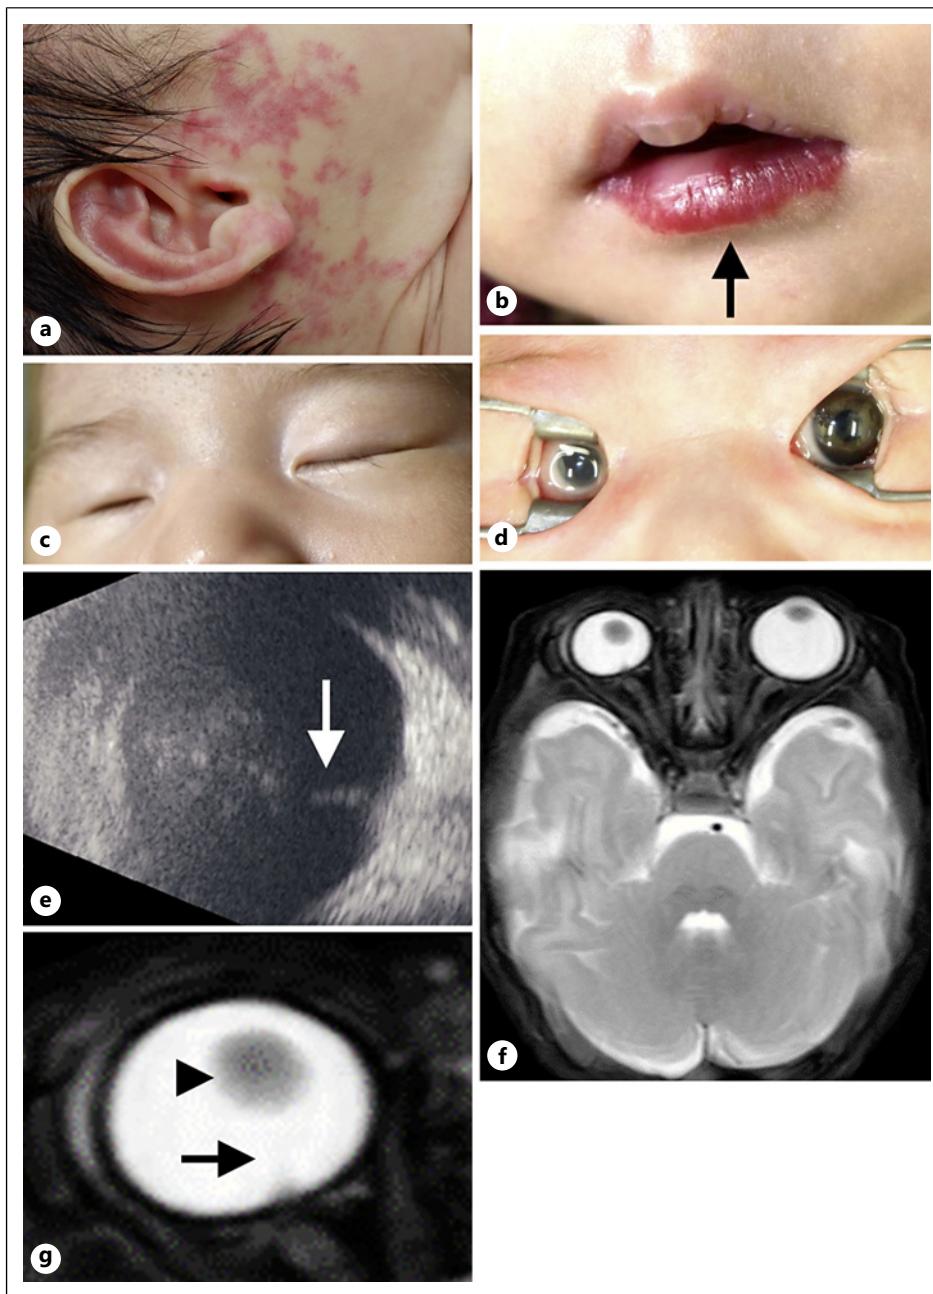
Findings at 3 weeks of age. a, b A female infant with IFH over the right periauricular area extends down the neck and cheek area (a) and lower lip (b, arrow). c A right small globe, pseudoptosis, and a narrow palpebral fissure. d A right microphthalmia and a clear microcornea. e Ocular B-scan showing hyperechoic lesions in the vitreous cavity and stalk extending from the ONH (white arrow). f MRI showing right microphthalmos with dysmorphic globe. g Right globe on MRI showing a dislocated spherophakic lens (arrowhead) and hypo-intense stalk extending from the ONH to the posterior lens capsule (arrow). ONH, optic nerve head.
